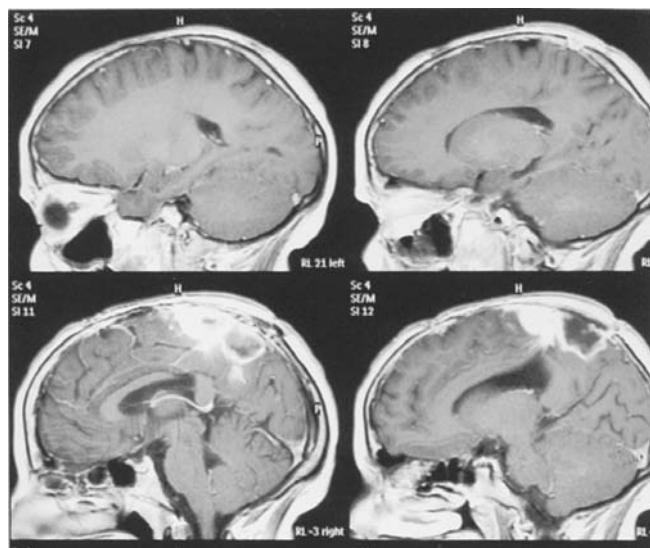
Four-month follow-up of sagittal Gd-enhanced T1-weighted MR scans clearly showing the recurrence by the side of the previous tumor bed resection and Gliadel® implant.
